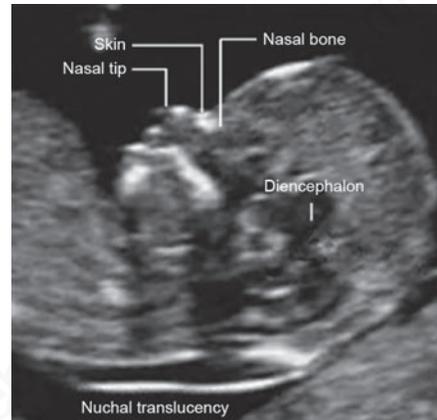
Nuchal translucency measurement by ultrasound
